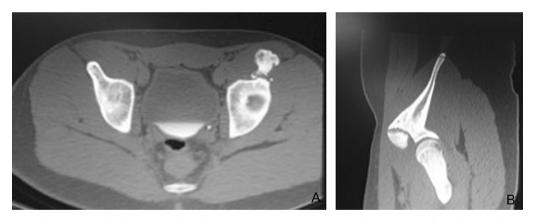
Axial CT scan showing anterolateral heterotopic bone formation over AIIS (A); Saggital CT scan showing anteroinferior heterotopic bone over AIIS (B).
